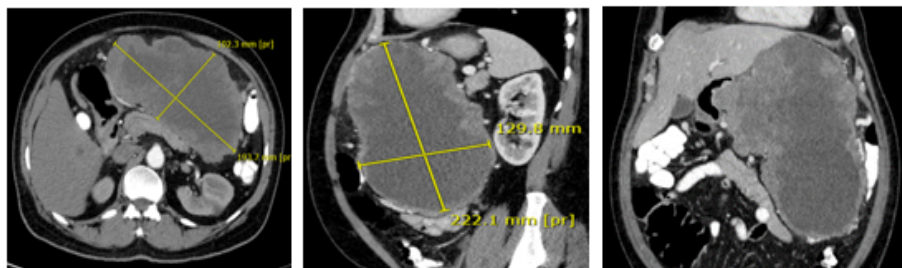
CT abdomen showed the mass size pre-treatment.
